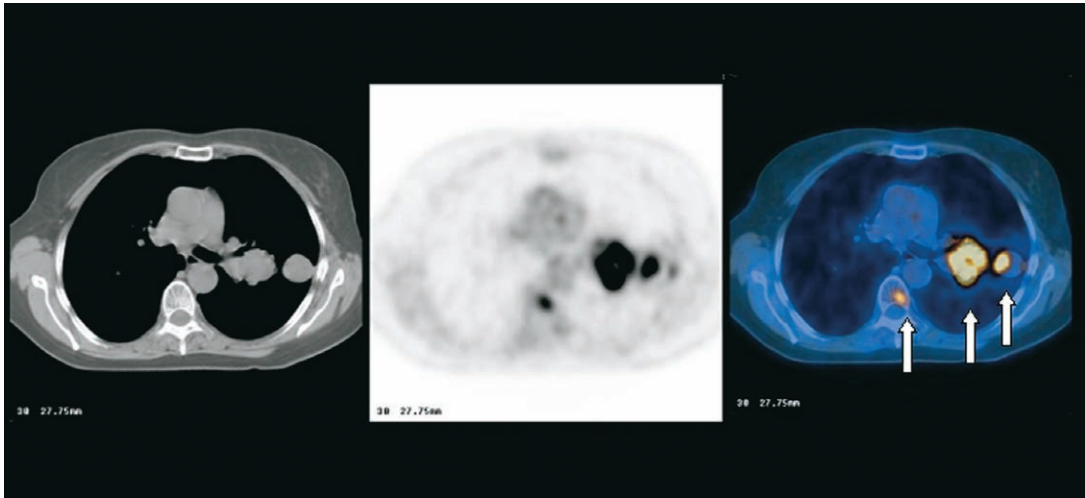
Selected transaxial slice demonstrating  $^{18}\text{F}$ -FDG-PET images in a 68-year-old woman who smoked 1 pack of cigarettes per day for many years. She presented to her primary care physician with complaints of back pain but was otherwise in good health. A chest radiograph revealed a hilar mass and lung nodules. Transbronchial biopsy was positive for poorly differentiated non-small-cell lung carcinoma. The patient was referred for evaluation of the extent of disease. The so-called hilar mass was actually the primary lung tumor adjacent to hilar structures with a nearby second and third focus. A metastatic lesion in the vertebral body was also demonstrated. The accompanying CT image shows multiple tumor masses and evidence of a sclerotic lesion in the vertebral body (lung CT window).  $^{18}\text{F}$ -FDG-PET indicates the extent of viable tumor. Recently, radiation treatment plans using intensity modulated radiation therapy (IMRT) were designed to provide booster radiation doses to the well-circumscribed viable tumor defined by  $^{18}\text{F}$ -FDG-PET as opposed to simply delivering the prescribed dose to the entire CT defined tumor volume. (Courtesy of Jacqueline Brunetti, MD, Department of Radiology, Holy Name Hospital, Teaneck, NJ).
